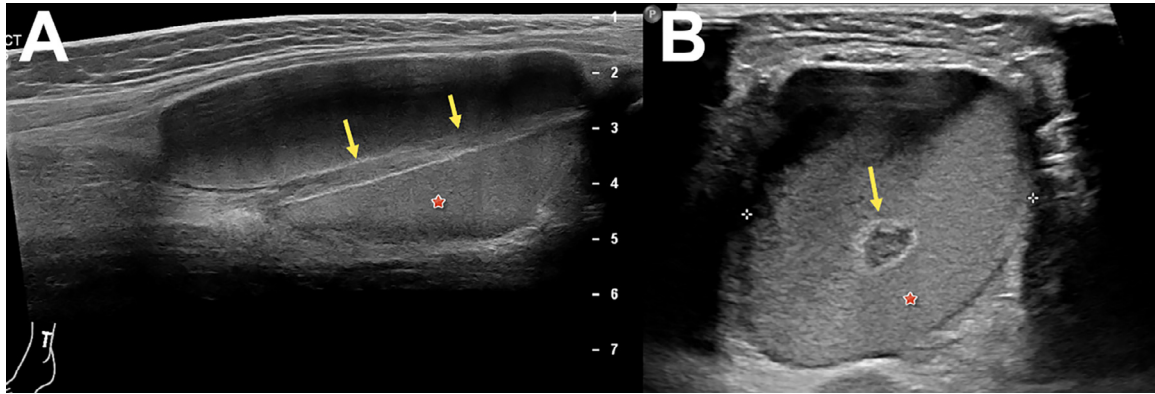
Sagittal (A) axial and (B) ultrasound images of the ankle lesion demonstrating a hypoechoic nonvascular fluid collection with layering debris (red star) and the flexor hallucis longus tendon coursing through the center of the lesion (yellow arrows).
